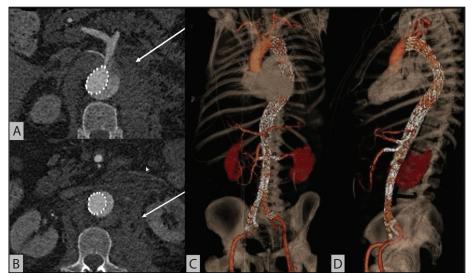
CTA showing the ruptured FL at the abdominal level (arrows) (A, B). Control CTA 3D reconstruction after total endovascular repair of the aorta with a branched off-the-shelf graft placed inside the previous uncovered aortic dissection stent and the right side iliac branch device (C, D).
